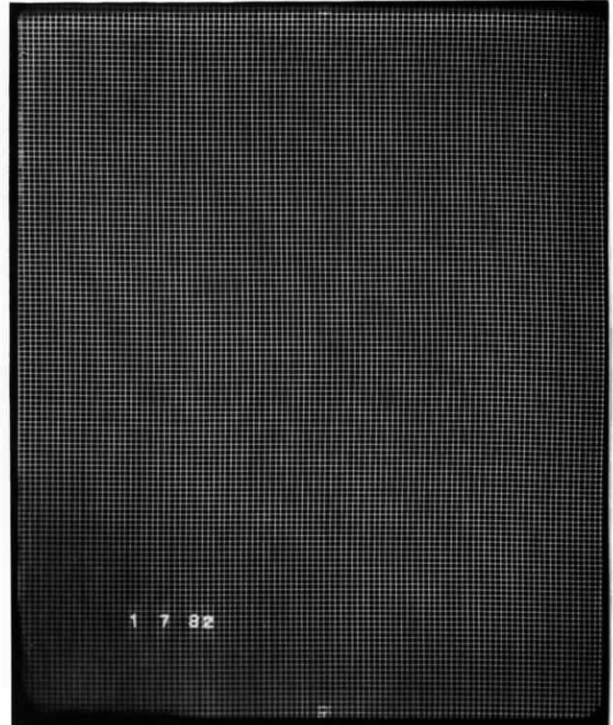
Increased density is apparent in the lower left corner of this radiograph of the mesh. Although this indicates unsharpness it may be necessary to accept this since it occurs on the edge of the image, which it is hoped is outside of the major area of interest.
